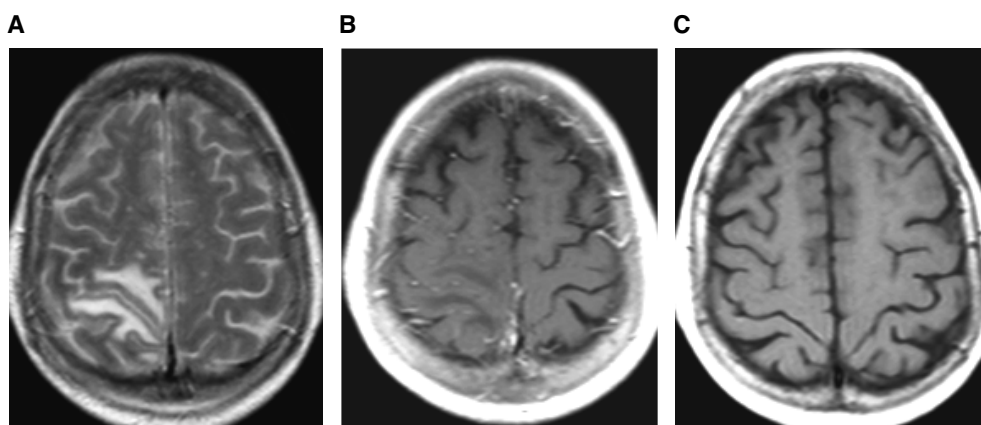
Cerebral MRI of the proband of family 1 during prolonged aura (A+B) and after full recovery (C). A+B: MR FLAIR T2-weighted image in axial plane and gadolinium-enhanced T1-weighted image showing a subcortical area of white matter in the perirolandic region on the right is hyperintense on image A and relatively hypointense on image B, with blurring of the cortical sulci adjacent to the convexity. C: T1-weighted MR image showing the resolution of the radiological abnormalities, in agreement with the patient's clinical recovery.
